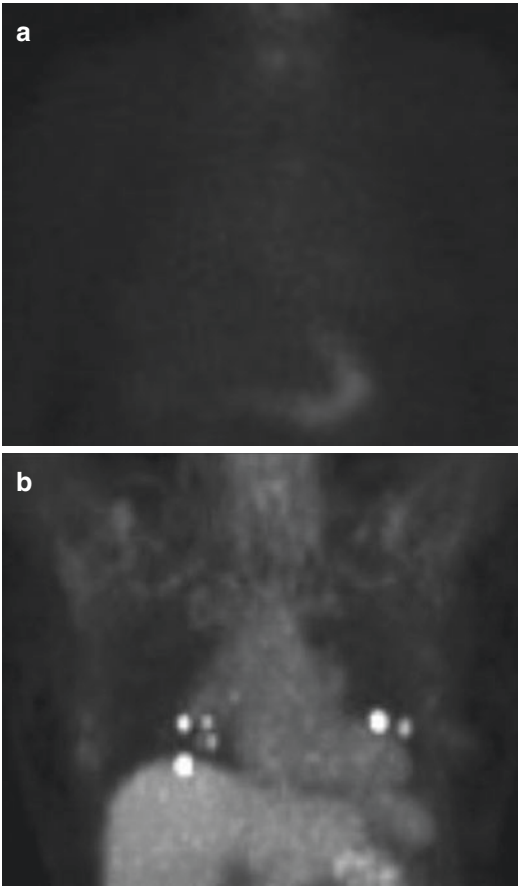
Comparison of nuclear imaging in a patient with pulmonary metastases from widely metastatic Hurthle cell carcinoma. (a) Chest series from a I-131 posttreatment whole-body radioactive iodine uptake and scan without any obvious metastases. (b) Chest series from an 18F-FDG-PET obtained 3 months prior during initial staging, revealing multiple foci of FDG uptake in the bilateral middle and lower lobes
